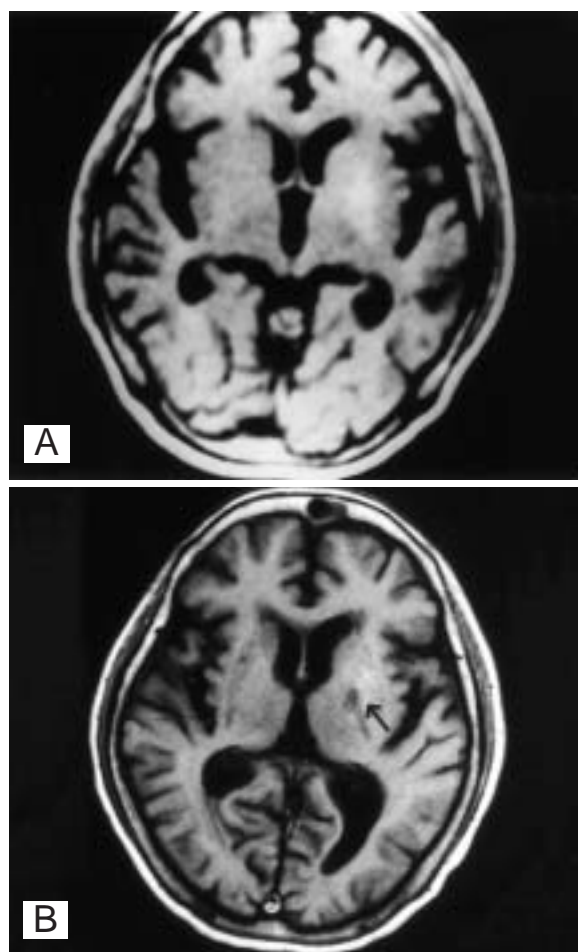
A: Preoperative MRI of case 2 on T1WI; B: postoperative MRI on T1WI. Operation lesions are marked with arrow head.
